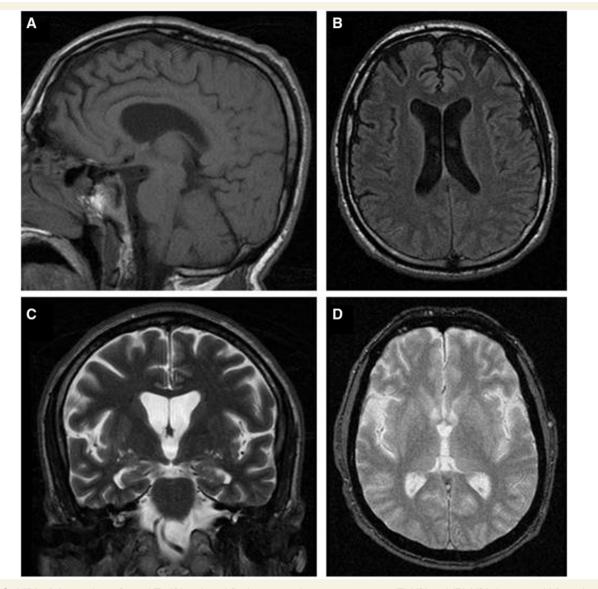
MRI of the patient. Sagittal T_1 (A) and axial fluid-attenuated inversion recovery (FLAIR) and (B) MRI showing mild frontal atrophy. Coronal T_{2^-} (C) and axial $T_{2^{*-}}$ (D) weighted acquisitions without basal ganglia hypointensities suggestive of iron deposition.
